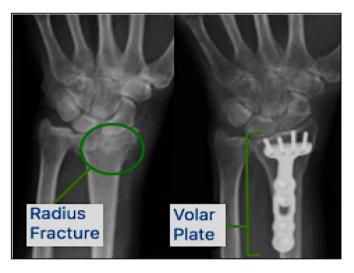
Left to right, preoperative radiograph showing distal radius fracture and postoperative radiograph with volar plate, adapted from [16].
